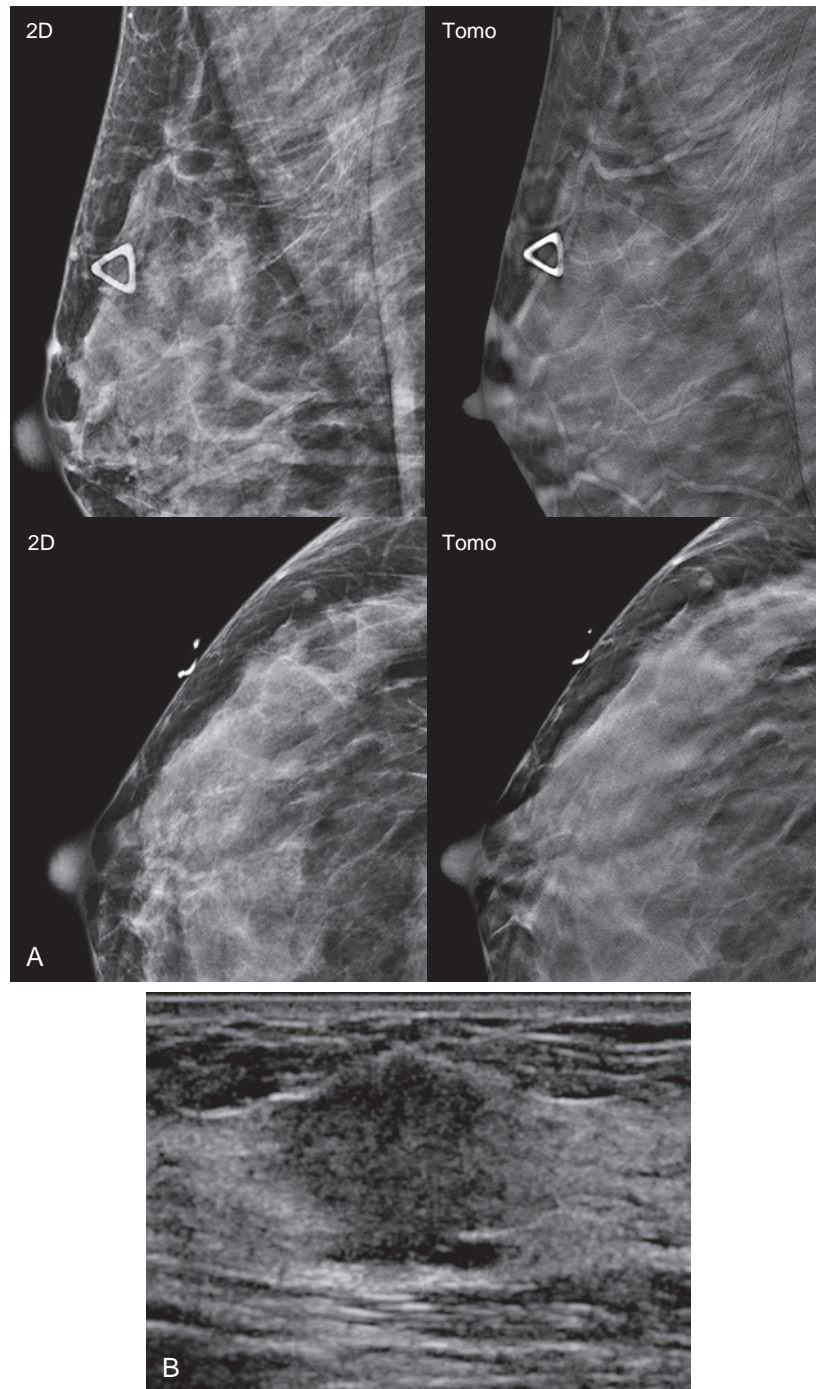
Tomosynthesis occult cancer. (A) Baseline mammogram in a 42-year-old woman with a new palpable mass in the right upper-outer breast shows dense breast tissue without evidence of any abnormality. (B) Targeted ultrasound in the region of palpable concern reveals a highly suspicious isoechoic mass with indistinct borders. Ultrasound-guided core needle biopsy and surgical excision yielded infiltrating ductal carcinoma, grade 2, ER/PR+, Her2–, 1+/ $\frac{1}{4}$ SLN.
